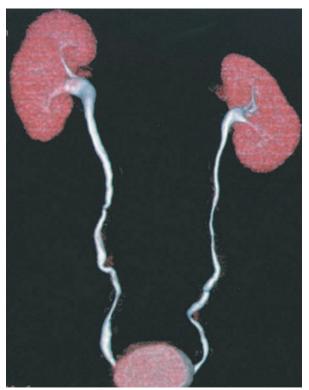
Noncontrast CT of bladder and kidney. Computer-reformatted, volume-rendered CT urogram obtained from axial CT acquisition.
